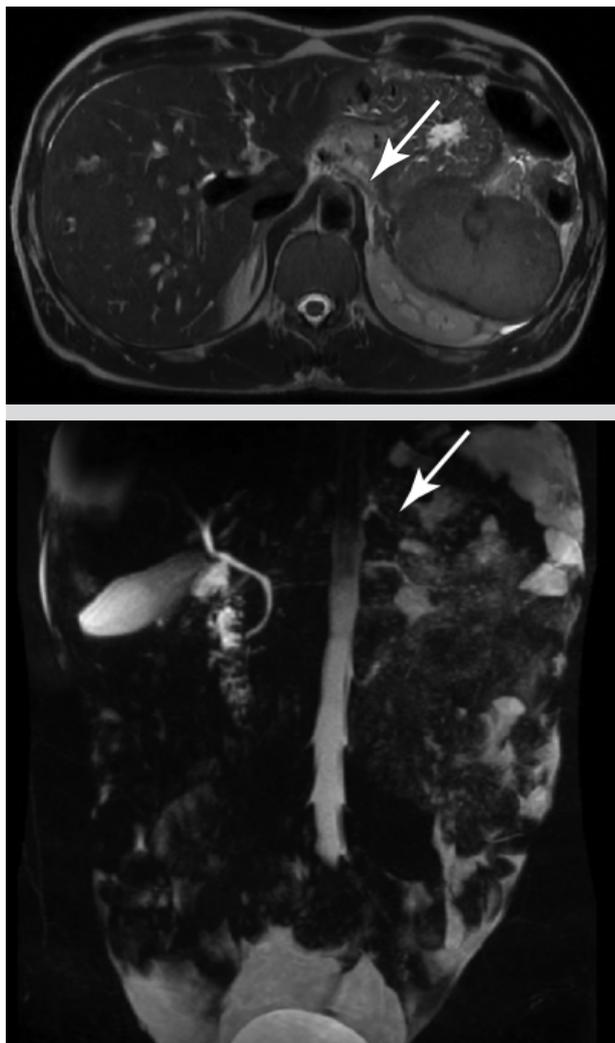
MRI findings (arrow) – linear structure at the projection of the splenic vein close to the left pedicle of the diaphragm
